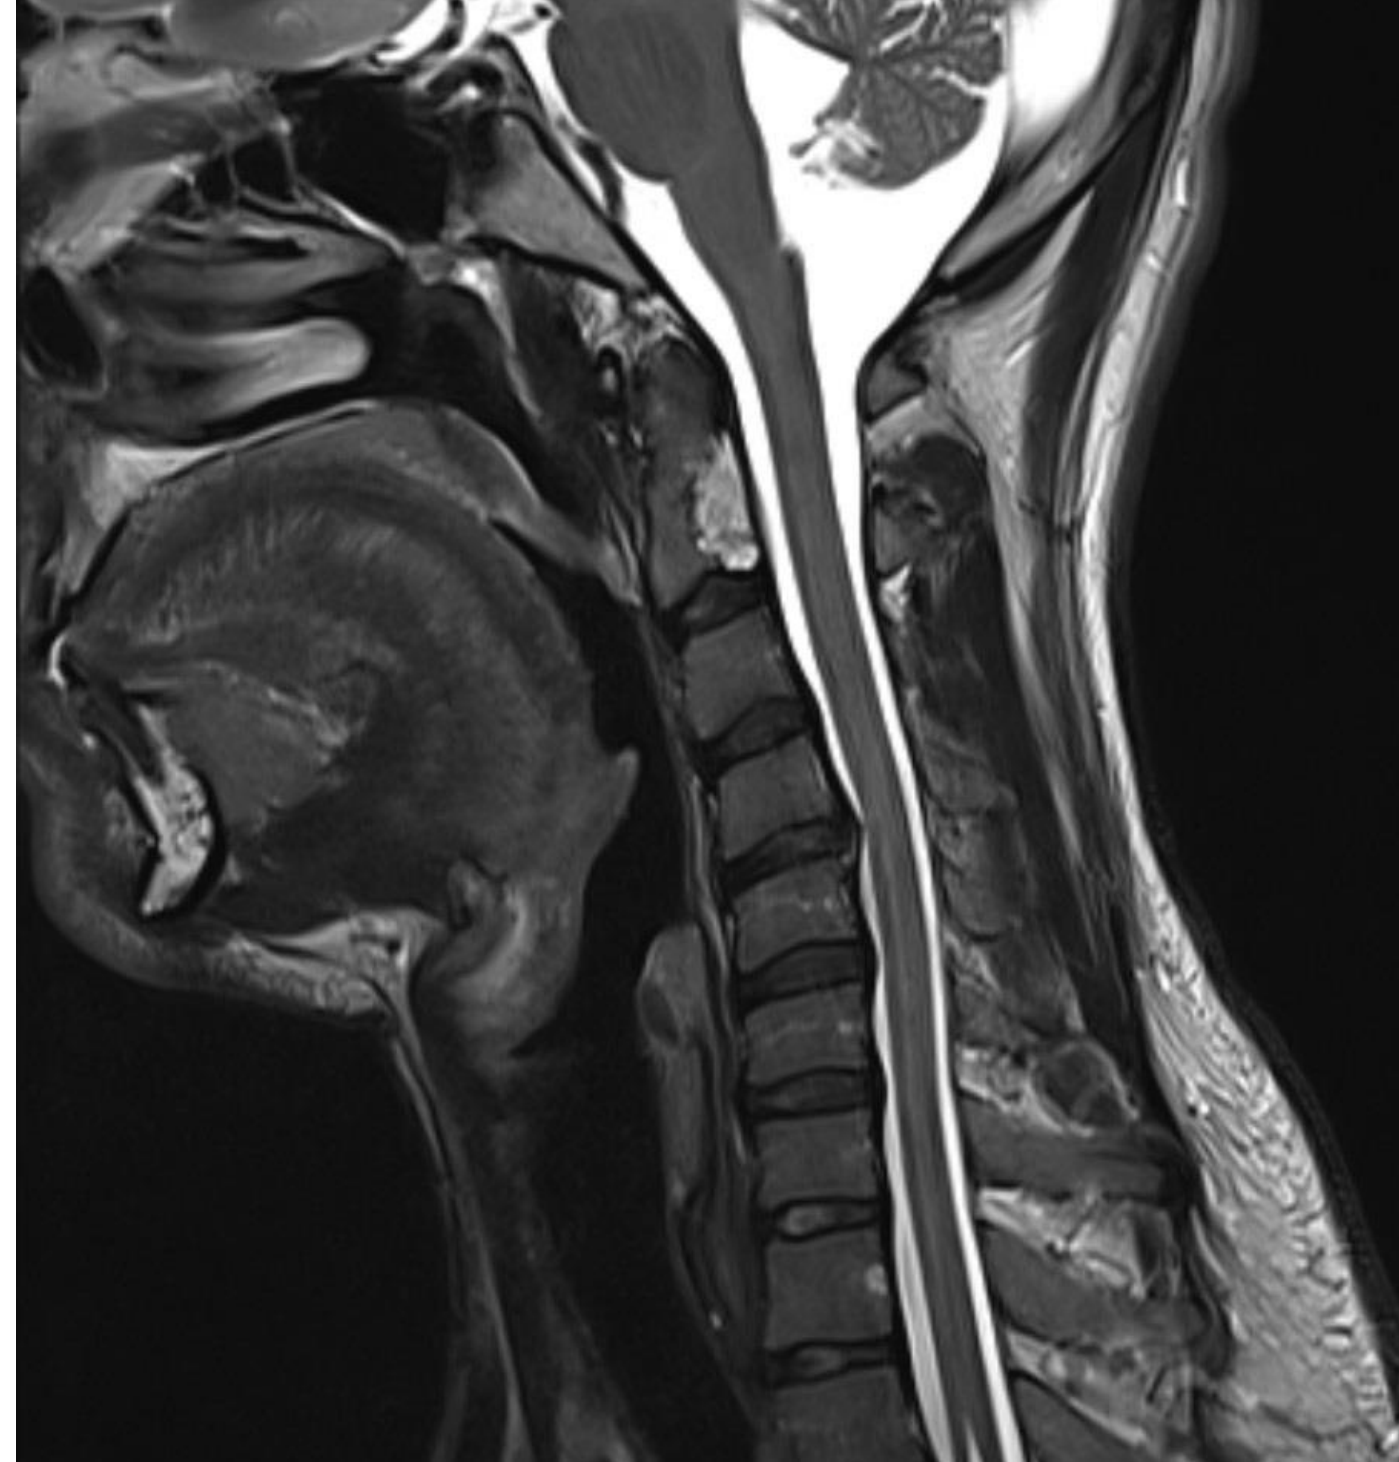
Sagittal MRI (T2) showing chordoma on posterior aspect of C2 vertebral body.
